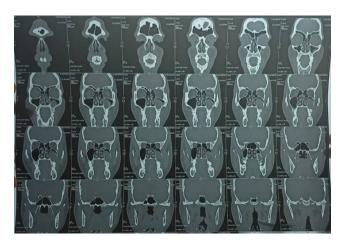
CBCT showing involvement of left maxillary sinus by the lesion
